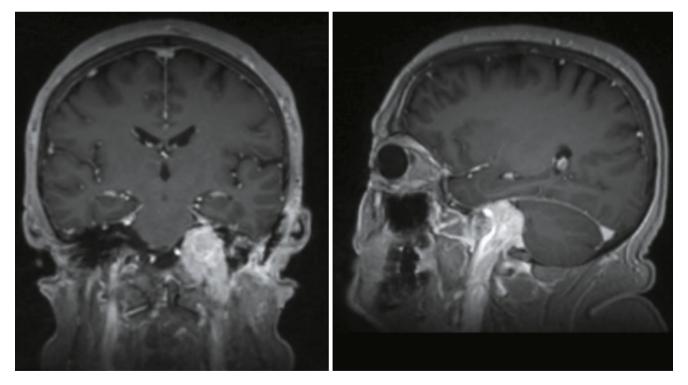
Postoperative MRI, (Left) coronal and (Right) sagittal
